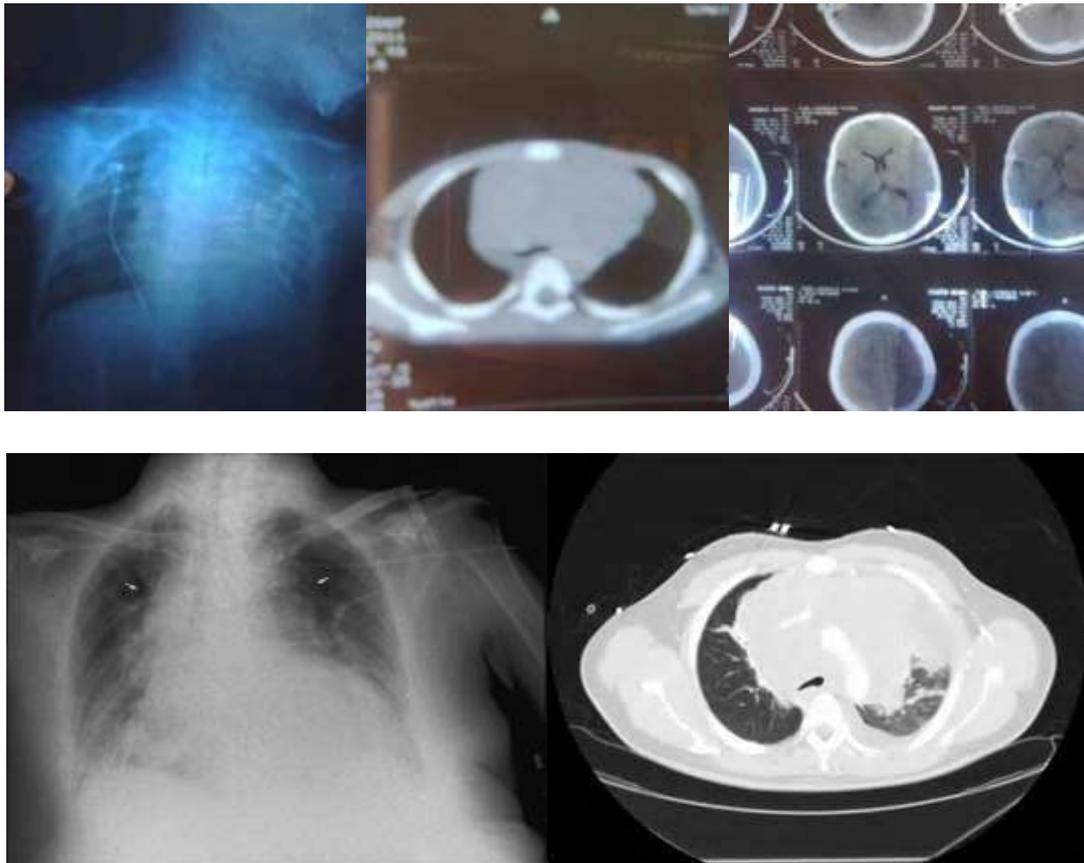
Chest X ray and CT show superior mediastinal mass with severe pressure on trachea and great vessels. CT brain shows absence of brain involvement.
